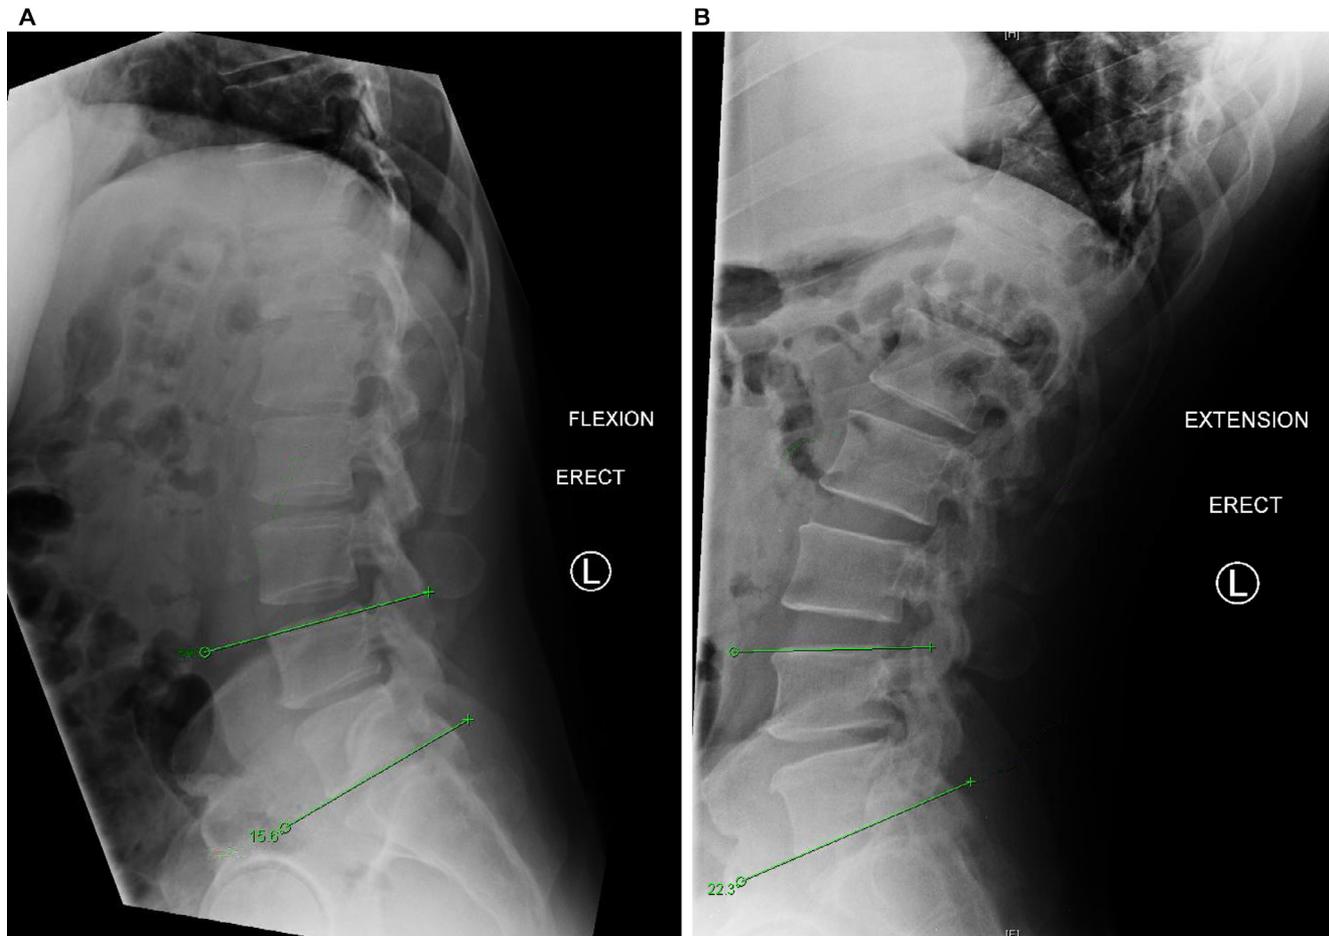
Flexion (A) and extension (B) lateral radiographs of the same patient. Note relative stability in flexion and extension, no spondylolisthesis noted. Patients may demonstrate dynamic instability or anterolisthesis that is not present on neutral film.
